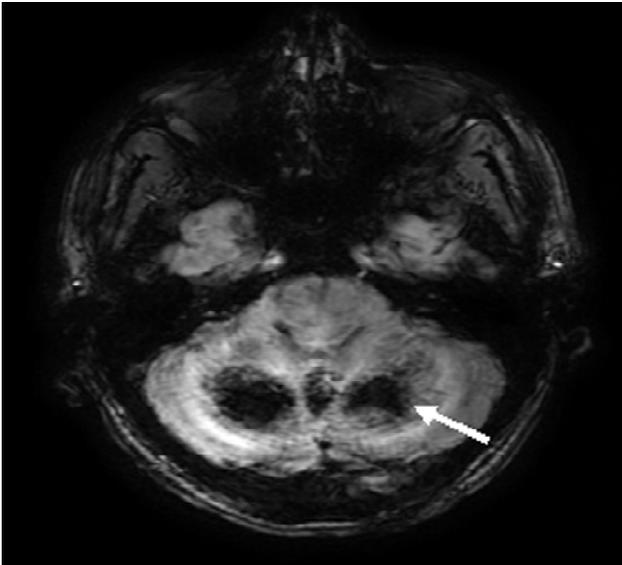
MRI 3D SWAN sequence showing haemorrhages in bilateral thalamus and cerebellum (pointed by white arrows).
